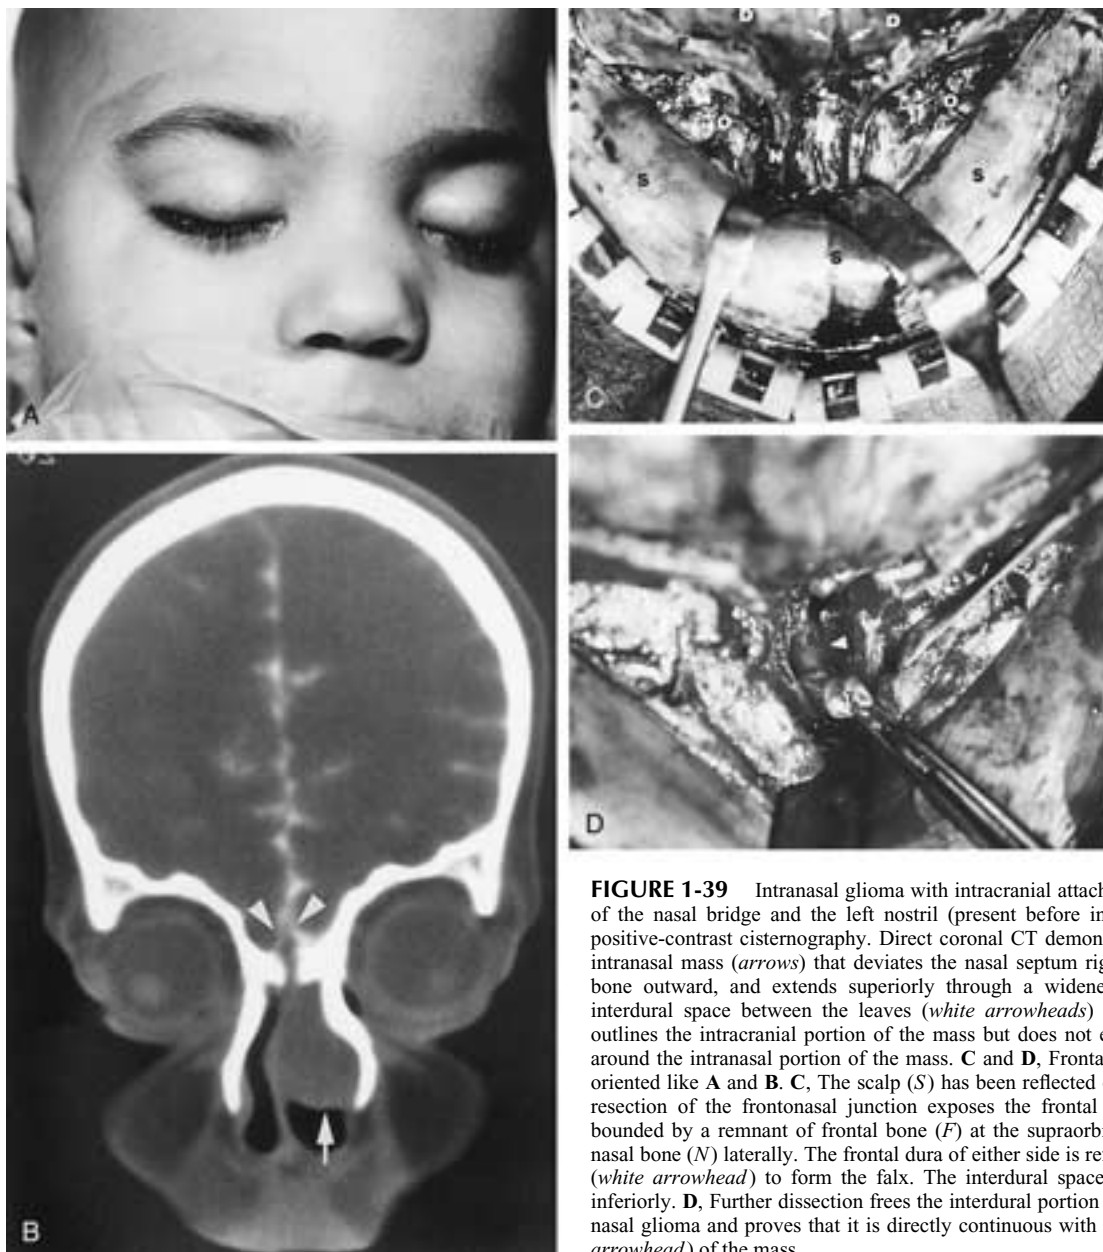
Intranasal glioma with intracranial attachments. A, Facies. Widening of the nasal bridge and the left nostril (present before intubation). B, Water-soluble positive-contrast cisternography. Direct coronal CT demonstrates a large left unilateral intranasal mass (arrows) that deviates the nasal septum rightward, bows the left nasal bone outward, and extends superiorly through a widened foramen cecum into the interdural space between the leaves (white arrowheads) of the falx. Opacified CSF outlines the intracranial portion of the mass but does not extend extracranially into or around the intranasal portion of the mass. C and D, Frontal intraoperative photographs oriented like A and B. C, The scalp (*S*) has been reflected over the orbits (*O*). Keyhole resection of the frontonasal junction exposes the frontal dura (*D*) and nasal cavity, bounded by a remnant of frontal bone (*F*) at the supraorbital ridges and a remnant of nasal bone (*N*) laterally. The frontal dura of either side is reflected inward in the midline (white arrowhead) to form the falx. The interdural space (white arrows) is widened inferiorly. D, Further dissection frees the interdural portion (between the forceps) of the nasal glioma and proves that it is directly continuous with the intranasal portion (white arrowhead) of the mass.
